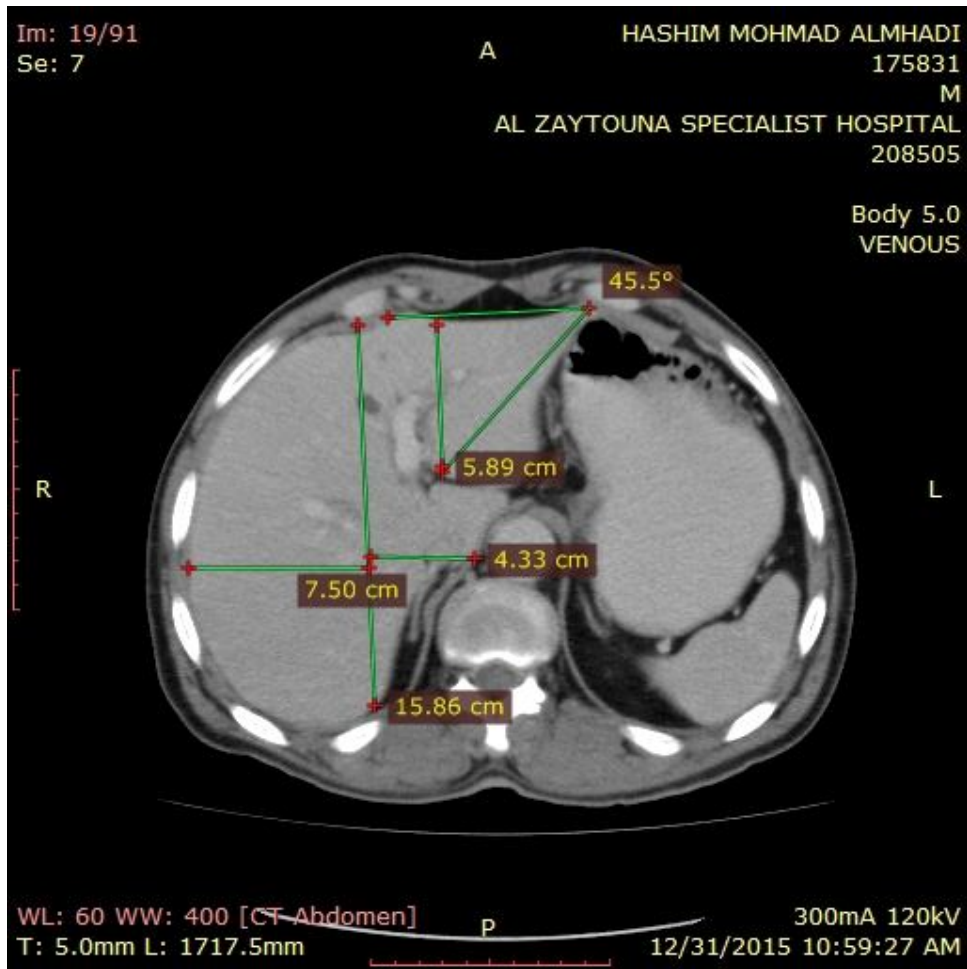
Fig CT liver axial venous phase the left hepatic angle- 45.5° AP diameter of the left hepatic lobe L-5.89 cm diameter of the right lobe-7.50 cm diameter of the caudate lobe-4.33 cm
